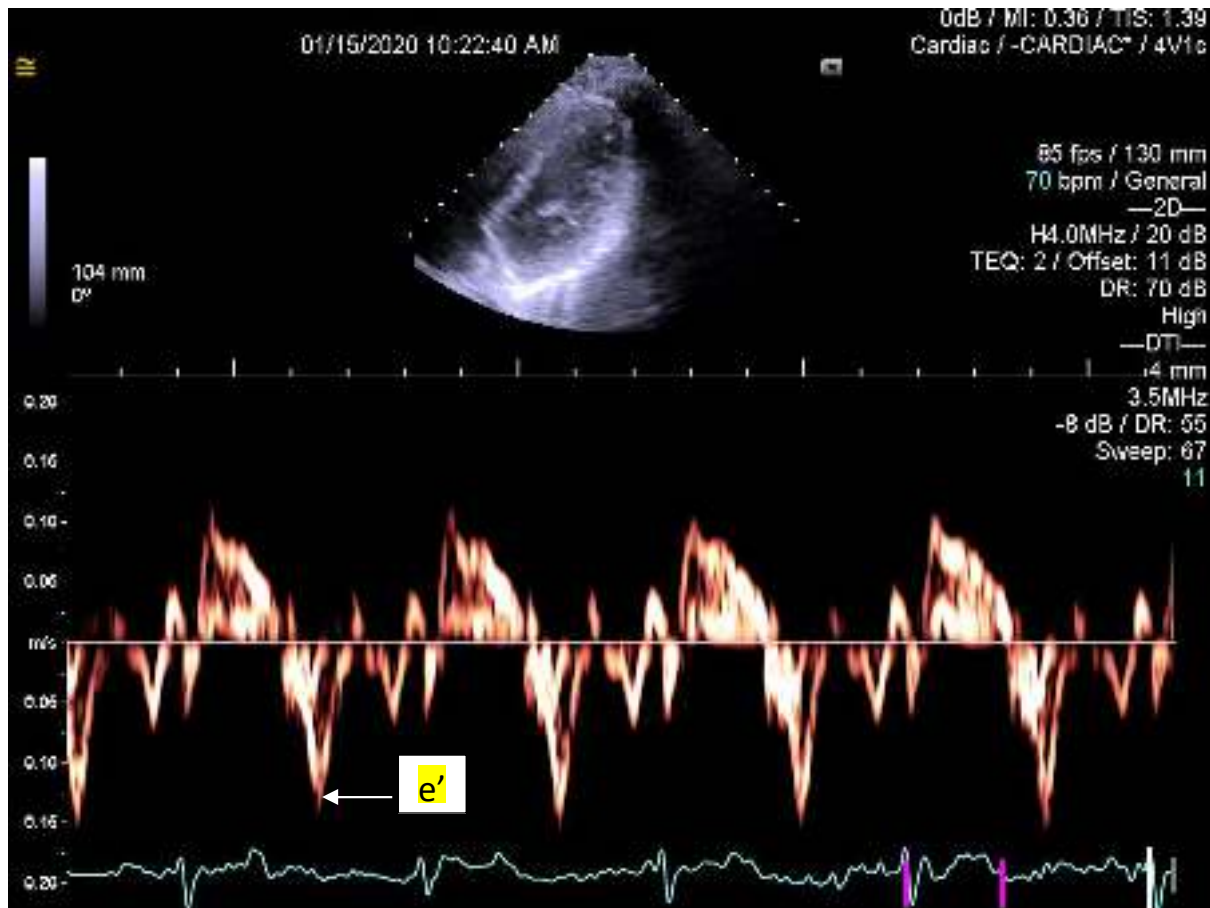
Septal Tissue doppler Myocardial Velocity. e' is the early longitudinal velocity of the myocardial septum.
